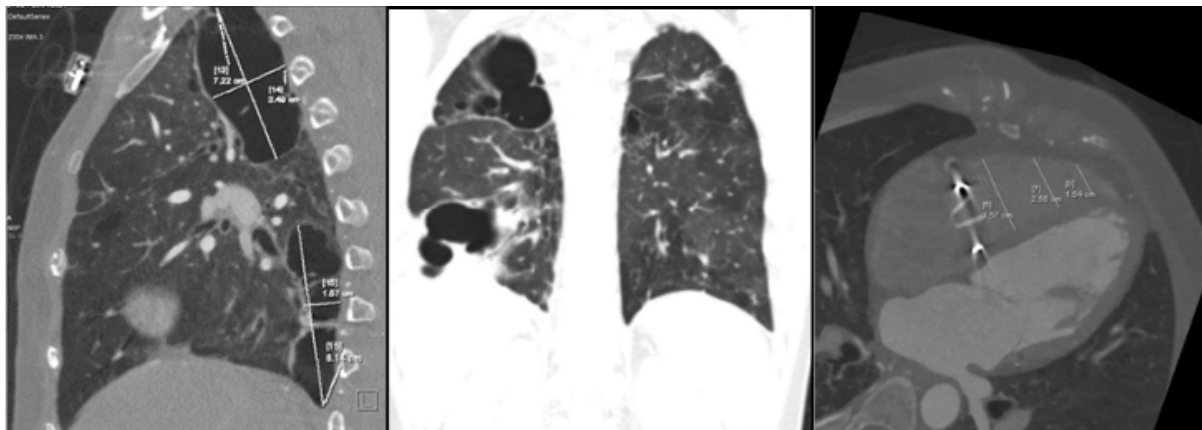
CT Scan of the patient, showing multiple bullae and a mechanical tricuspid valve
